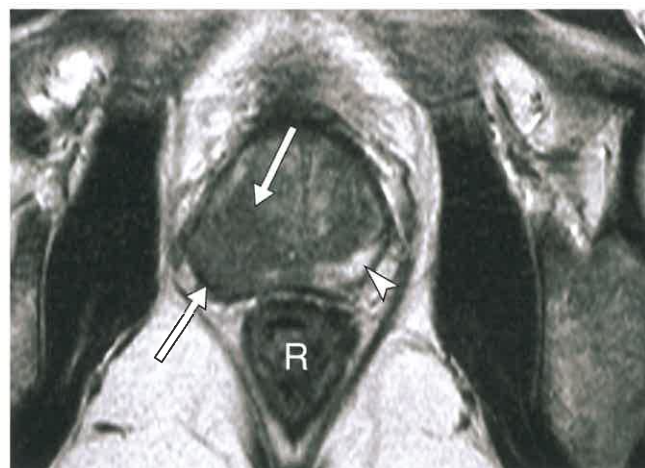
Prostate Carcinoma. Axial T2-weighted MR image of the prostate shows a low signal intensity adenocarcinoma (between arrows) replacing most of the peripheral zone and extending into the central gland of the prostate on the right. The peripheral zone on the left (arrowhead) remains normal high signal intensity. R, rectum.
